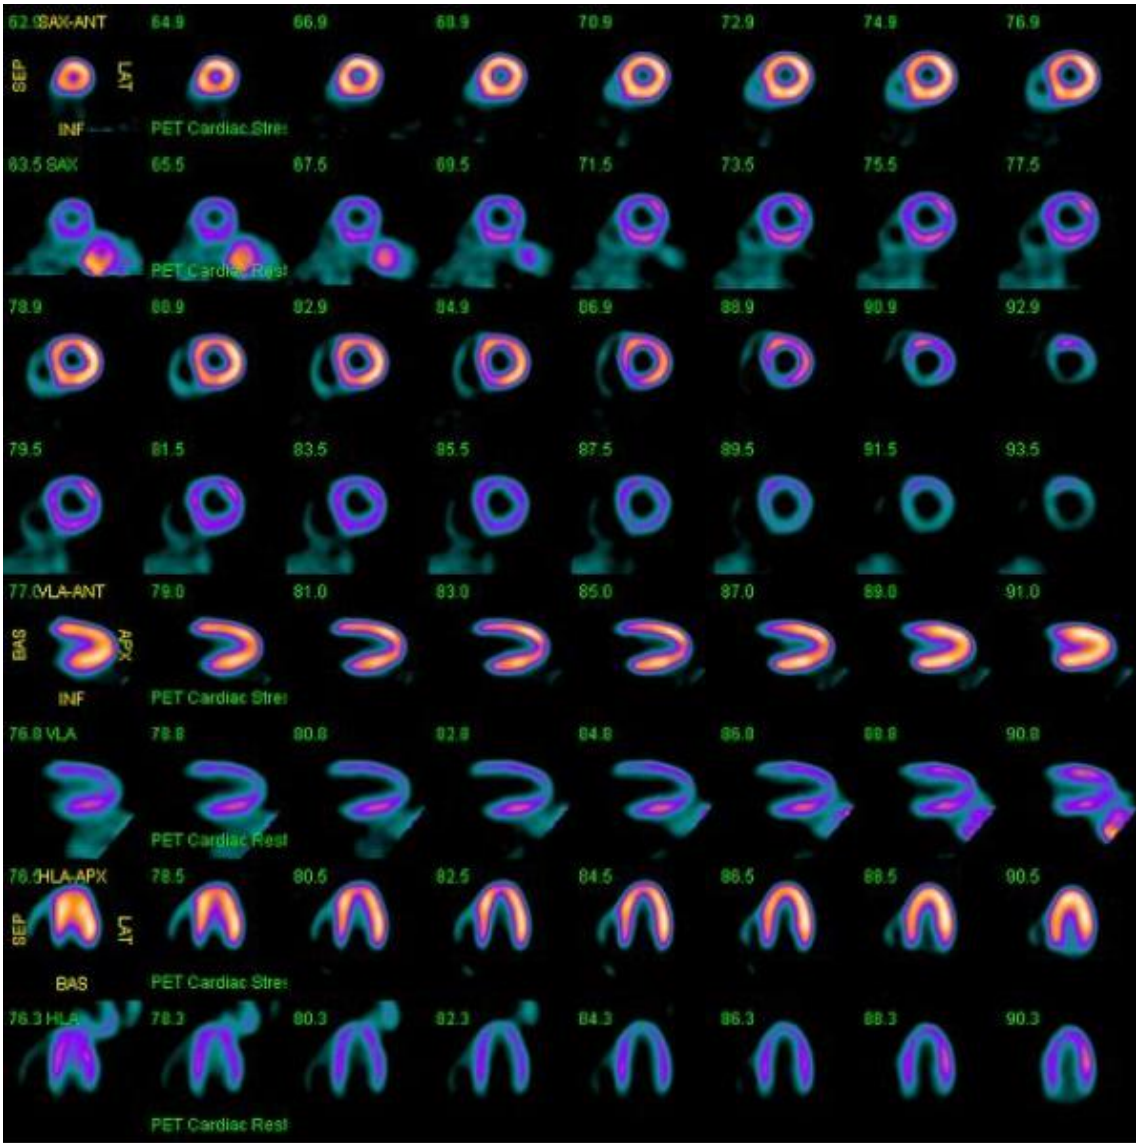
The transaxial non-gated static SPECT image (1<sup>st</sup> and 2<sup>nd</sup> rows from the top) and PET-CT image (3<sup>rd</sup> and 4<sup>th</sup> rows). There is a reversible defect seen affecting the posterior wall of left ventricle which filled up during FDG PET-CT study in keeping with a reversible ischaemic myocardial segment.
